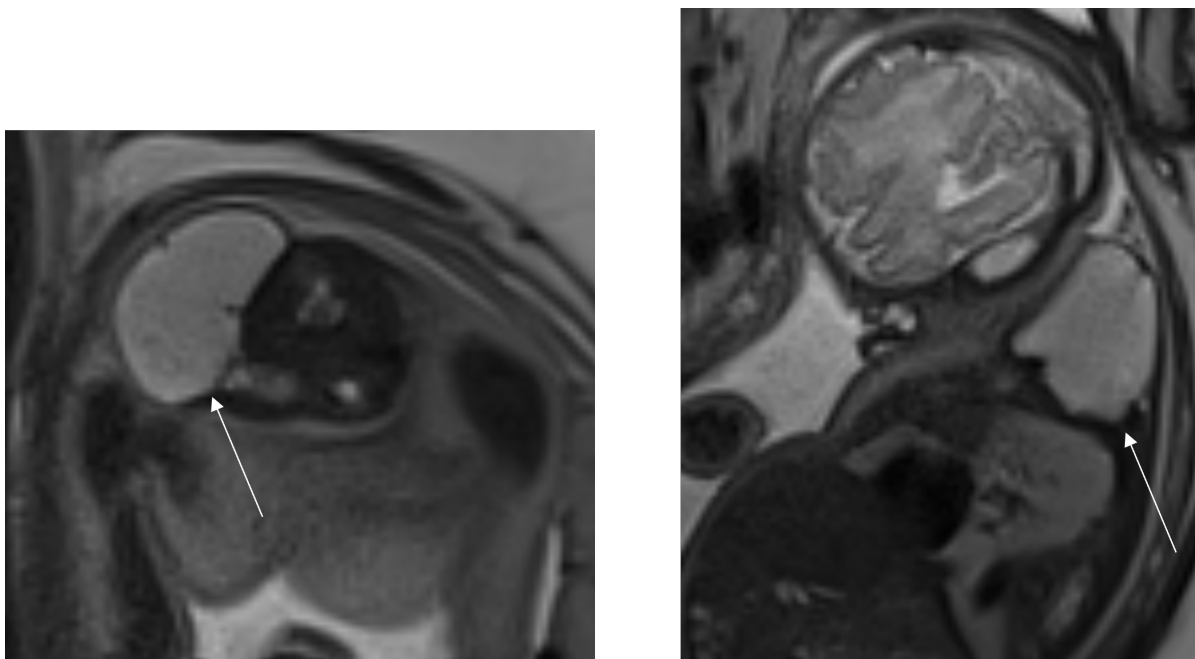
Fetal MRI images of a macrocystic lymphatic malformation (documented as cystic hygroma)
